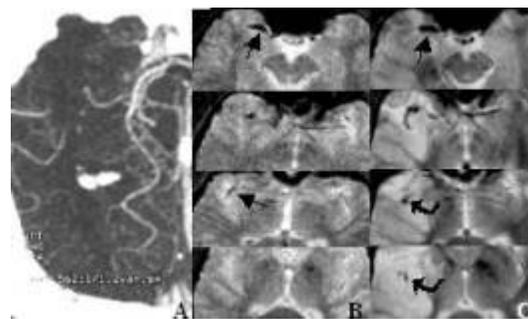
Right MCA occlusion. M1 and M2 are absent on CTA at 2.5 hours after symptom (A). SI at 2.75 hrs (B) shows the SS at MCA stem and proximal of M2 (arrows). Follow-up SI at day 3 (C) shows a larger SS corresponding to the initial CTA. The SS growth probably suggests diamagnetic oxyhemoglobin in acute thrombus transfers into paramagnetic deoxyhemoglobin and showed on follow-up SI (curve arrow).
